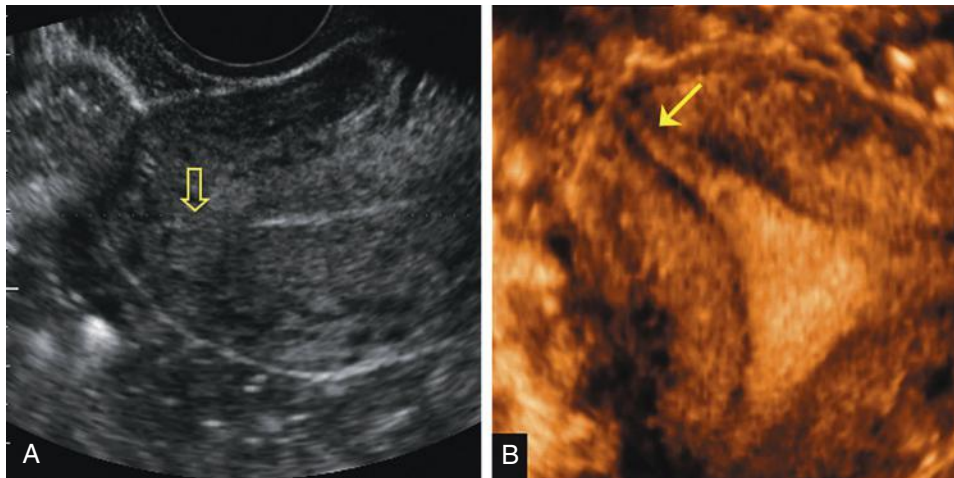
Interstitial portion of the fallopian tube. A, Transverse transvaginal scan of the uterine fundus showing a thin echogenic line extending from the cornual portion of the endometrium toward the serosal surface of the uterus representing the interstitial portion of the fallopian tube (*open arrow*). B, Three-dimensional (3D) coronal view of the uterine fundus showing the echogenic, triangular endometrial canal and the interstitial portion of one fallopian tube (*arrow*) extending to the serosal surface. On 3D sonography, this portion of the tube appears thicker than its true size.
